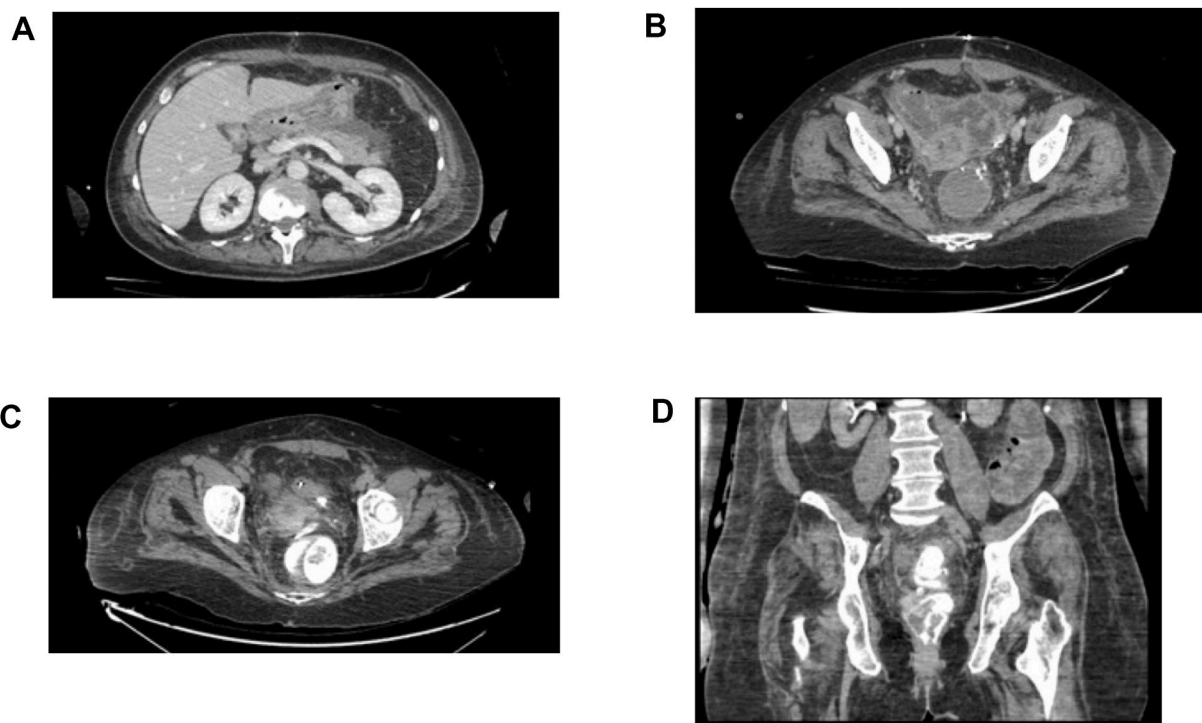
A. CT-scan documenting peripancreatic collection (indirect sign of AL in a patient with dissection of the splenic flexure). B. Same case. Collection close to the colorectal anastomosis. C. CT-scan with contrast enema. The leakage of the contrast is highlighted with an initial opacification of the drainage. D. Longitudinal reconstruction of previous CT-scan.
